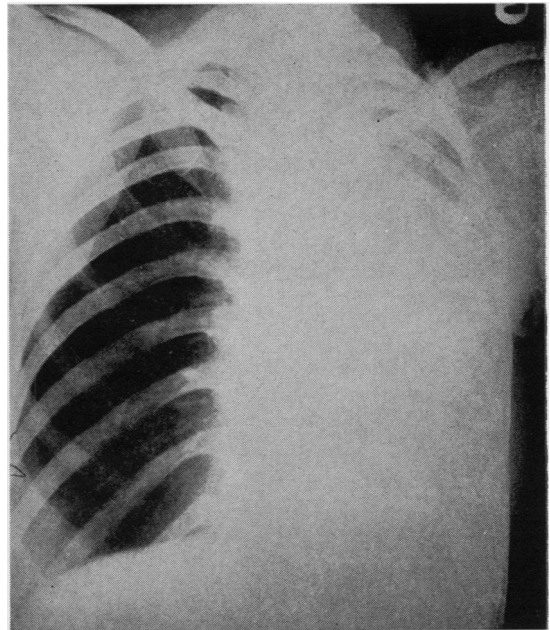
Radiograph of Case 1, showing total collapse of the left lung on her second admission.
